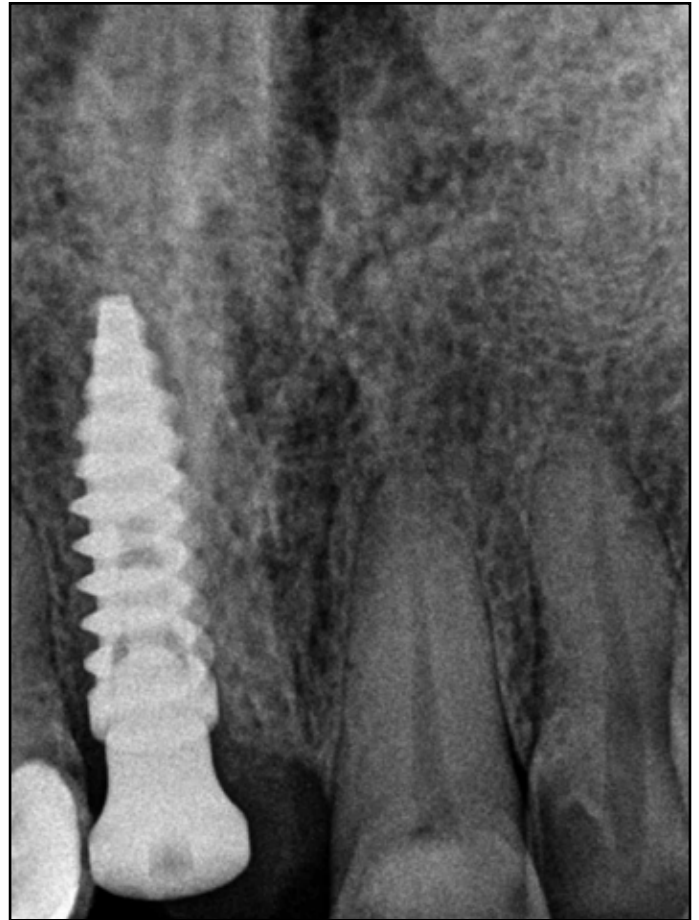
Periapical radiograph immediately following implant and graft placement with a healing abutment placed.
